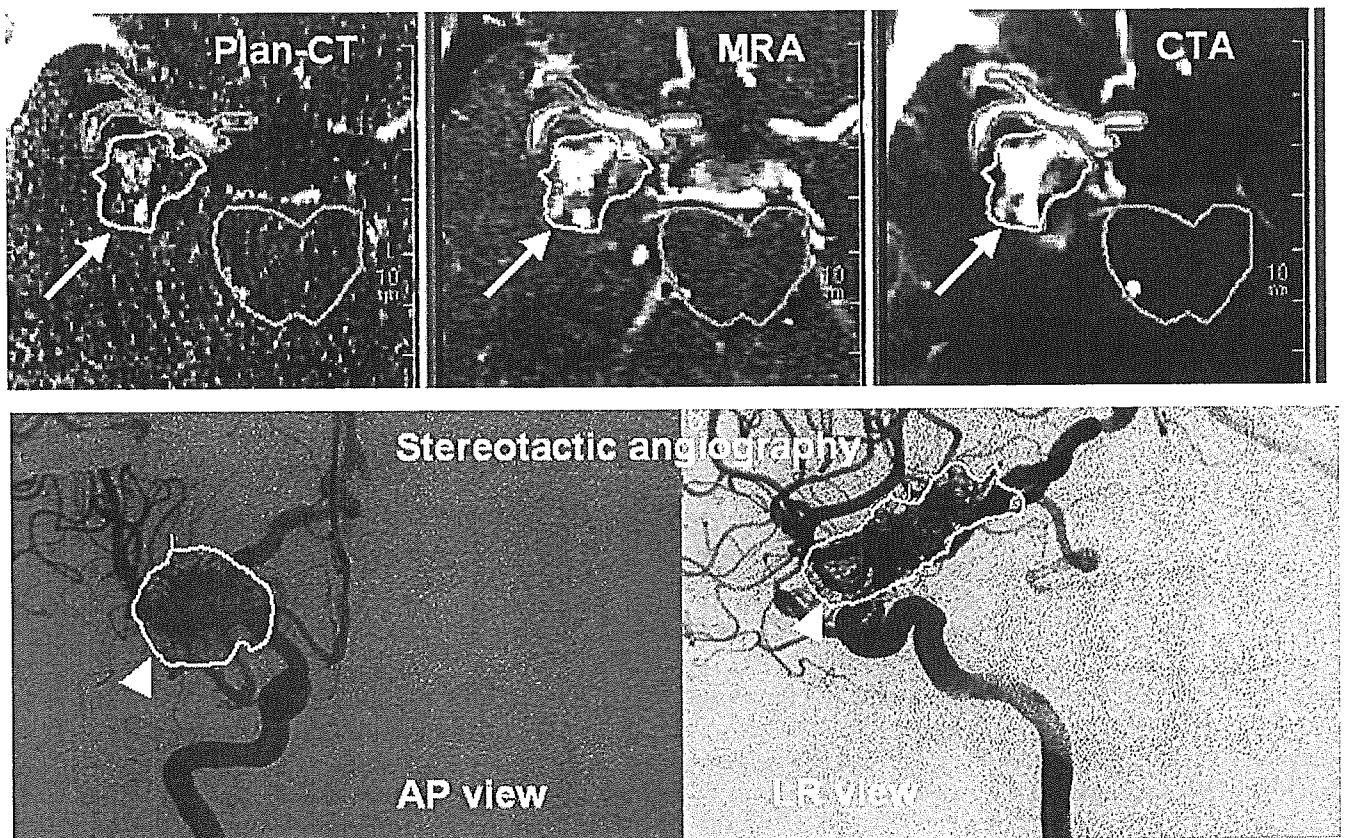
A case in which the arteriovenous malformation (AVM) target was delineated on coregistered contrast-enhanced computed tomography (CT), contrast-enhanced magnetic resonance angiography (MRA), and computed tomographic angiography (CTA) (arrow). Target on AP and LR view of stereotactic angiography are also shown (arrowhead). AP = anterior-posterior; LR = left-right.
